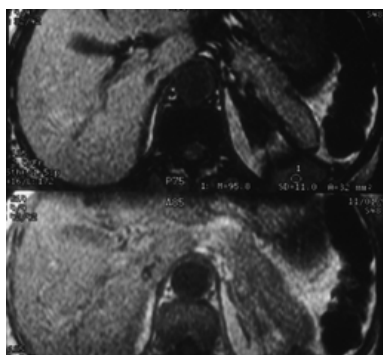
19. Chemical shift magnetic resonance imaging to determine that an adrenal mass is benign. *Top image* is an out-of-phase T₁-weighted scan that demonstrates a low-signal left adrenal mass. *Bottom image* shows an increase in signal in the same lesion when scanned with an in-phase T₁-weighted scan. The decrease in signal within the left adrenal mass is highly suggestive of a benign process such as an adrenal adenoma or hyperplasia.
